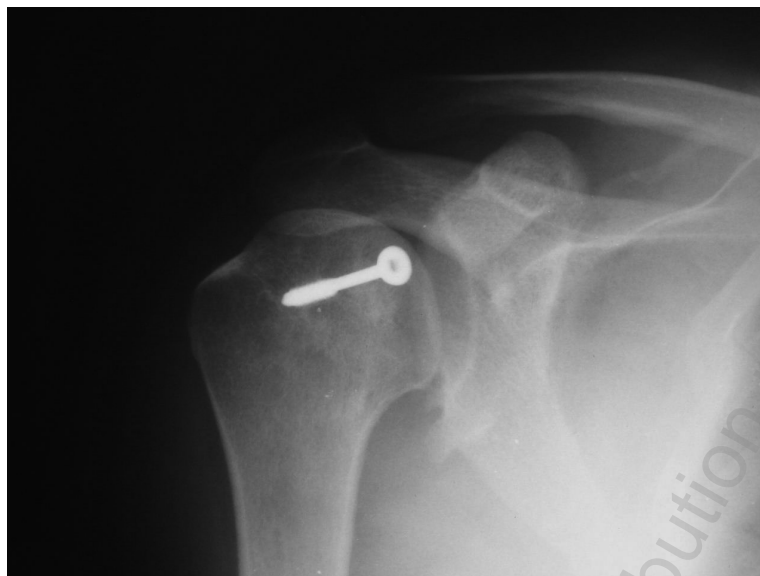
Postoperative X-ray 40 months later
